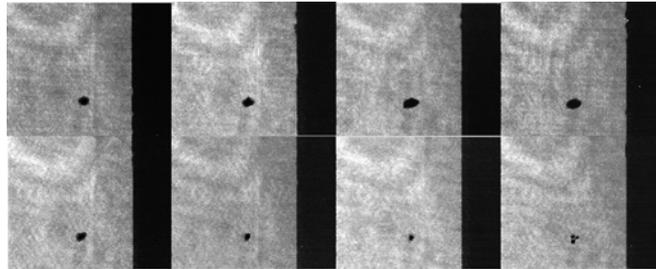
Photographic series of the interaction of a BR14 microbubble contrast agent with high-intensity focused ultrasound. Frame interval  $2 \mu\text{s}$ , frame size  $2.56 \text{ mm} \times 2.09 \text{ mm}$ .
